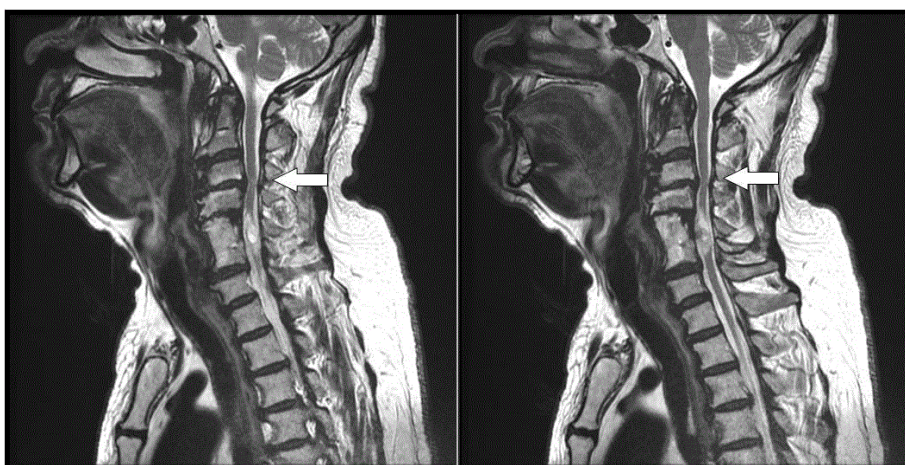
Sagittal T2 magnetic resonance image demonstrating spinal cord injury with focal high signal intensity spinal cord lesion
